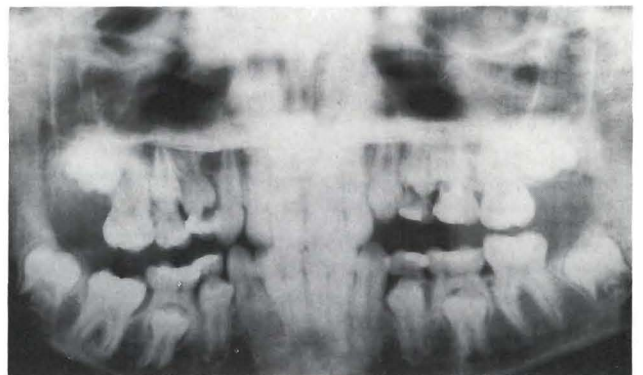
Orthopantomogram of a twelve-year-old girl with secondary retention of the left first and second primary molars and right first permanent molar in the mandible.
